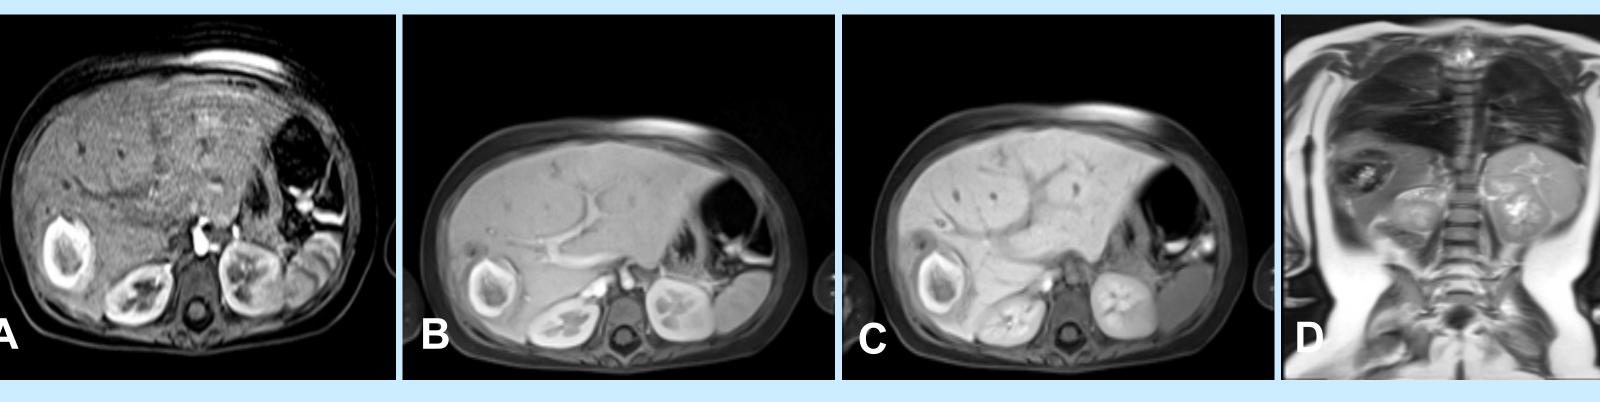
MRI post-therapy demonstrating an ablation cavity in segment VII with no enhancement on (A) T1 arterial (B) T1 venous or (C) T1 delayed contrast phases. The hyperintense T1 signal and hypointense (D) T2 signal is most consistent with inflammatory changes and tumor necrosis.
